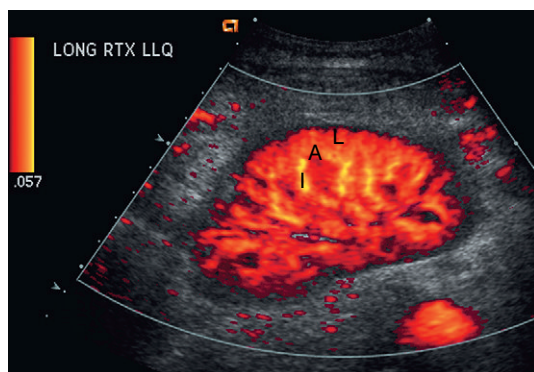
Longitudinal power Doppler image of a normal renal transplant. With the setting set to a very sensitive level, flow can be perceived in the interlobar (I), arcuate (A), and intralobular (L) arteries all the way out to the capsular surface of the kidney. This is a normal finding and indicates good renal perfusion with normal resistance to inflow.
